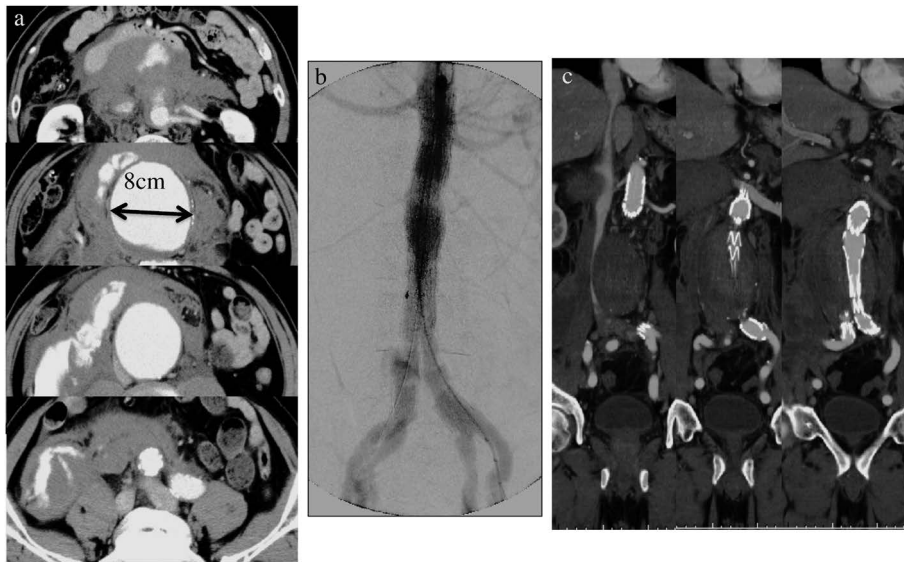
A case of RAAA treated by EVAR. (a) Fitzgerald grade III RAAA. (b) RAAA was successfully treated by EVAR with Zenith Flex (Cook Medical Incorporated, Bloomington, IN, USA). (c) Postoperative CT scan showed successful aneurysm exclusion without endoleak.
